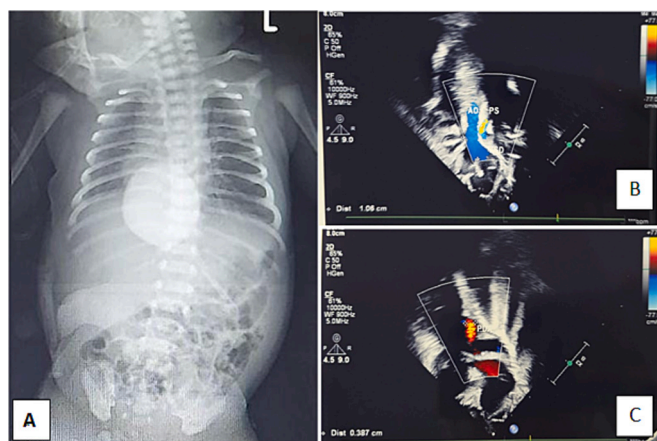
(A) Thoracoabdominal x-ray resulted radiopaque mass in the midline. (B and C) Echocardiography conclude Tetralogy of Fallot, Large PDA, Large ASD.
